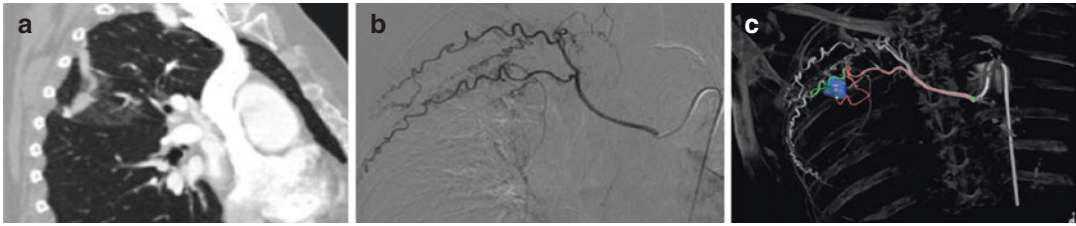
(a) CTA shows a small bleeding from a right intercostal artery. (b) DSA confirms the presence of a little contrast medium extravasation from the same vessel.
